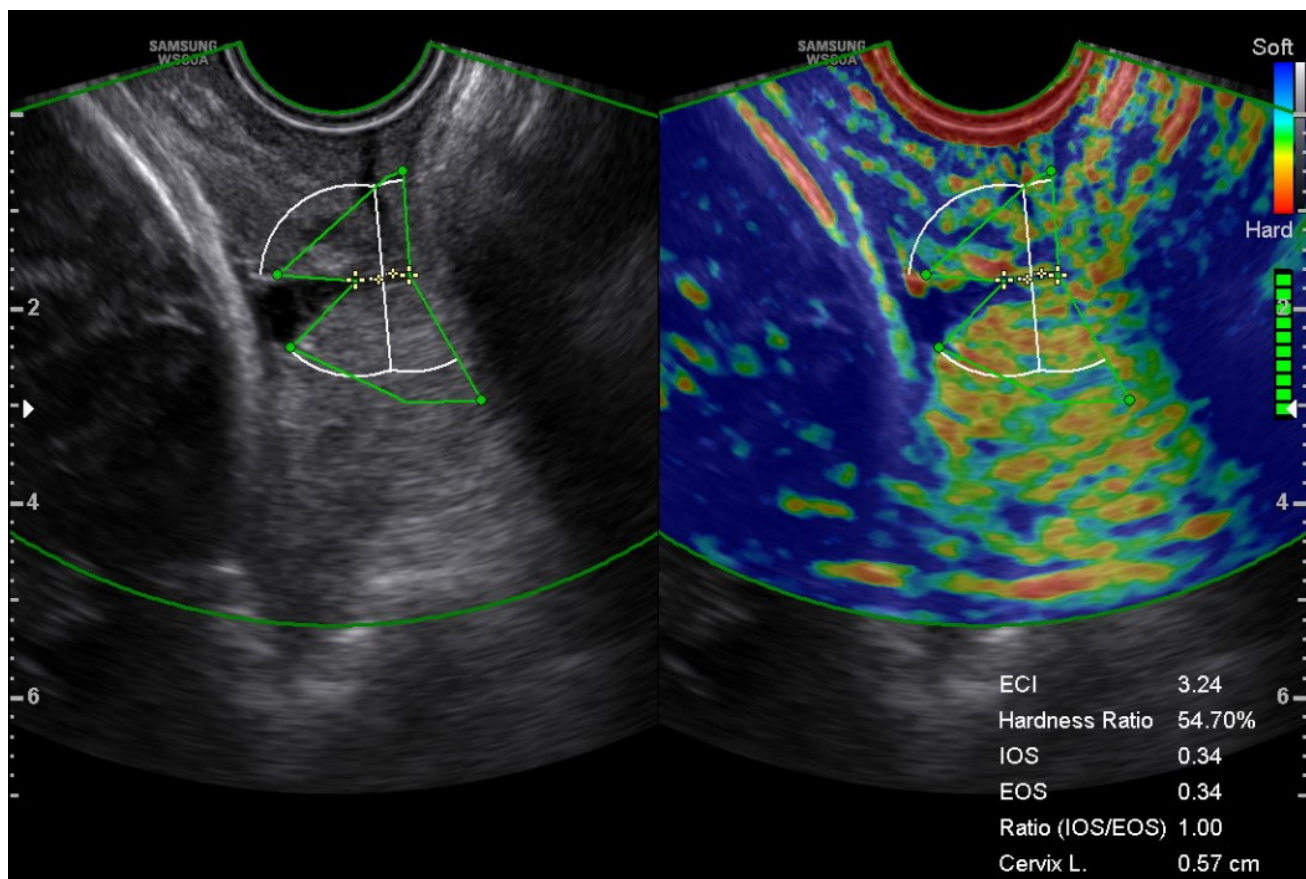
Transvaginal grayscale sonography and elastography images. The basic characteristics of this pregnant woman: 29 years old, height 1.64 m, 40 weeks gestation, pre-delivery body mass index (BMI) 24.91 kg/m², weight gain 9 kg during pregnancy. The Bishop score: 5. Cervical elastography ultrasound parameters: cervical length 0.57 cm, cervical hardness ratio 54.7%, cervical internal opening shape Y, cervical transverse width 0.9 cm, internal/external os (IOS/EOS) ratio 1. ECI, elasticity contrast index; Cervix L, cervical length.
